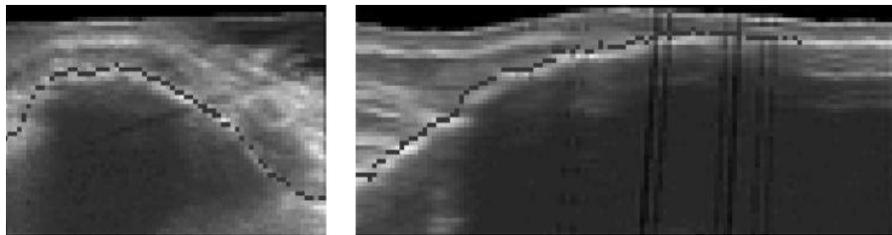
Registration of an in vivo dataset of a human tibia. Shown are an axial (left) and a sagittal (right) slice through the three-dimensional ultrasound dataset in the area of the tuberositas tibiae. The gray lines indicate the position of the bone surface extracted from the CT-dataset after registration.
